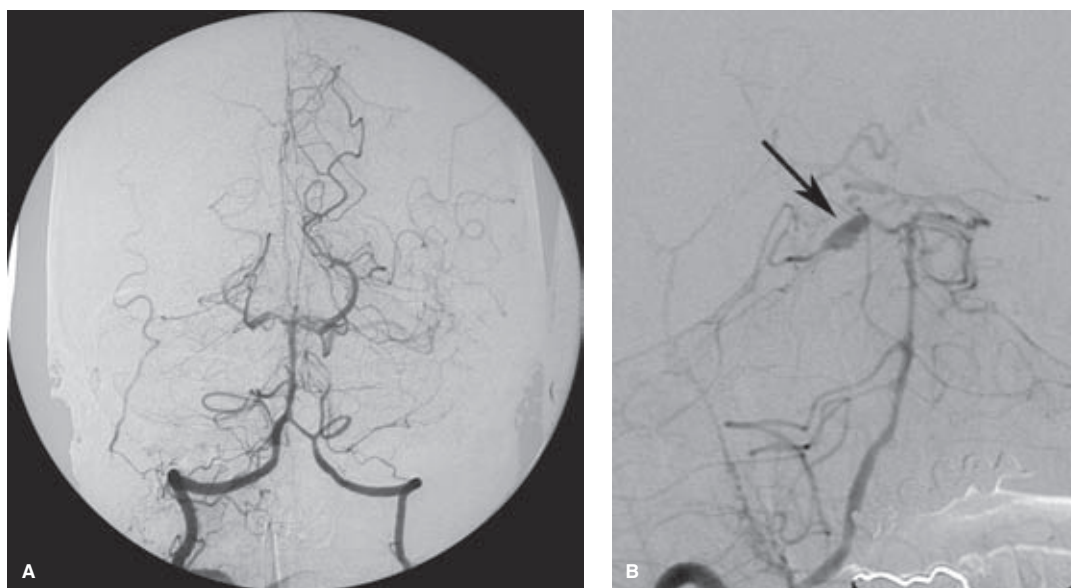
(A–B) Angiographically negative subarachnoid hemorrhage. A middle-aged patient presented with subarachnoid hemorrhage and had a negative arteriographic workup. Because of suspicion raised by the pattern of profuse hemorrhage on CT, an early follow-up angiogram was performed a few days later (Townes view of left vertebral artery in A). This shows subtle irregularity or complexity in the region of the overlap between the hypoplastic P1 segment and the right superior cerebellar artery. A magnification oblique view (B) demonstrates a dissection of the right superior cerebellar artery (arrow), which had eluded attention on the first angiogram. Its conspicuity on this second angiogram is accentuated by the presence of diffuse early vasospasm of the posterior circulation, not present on the first angiogram.
